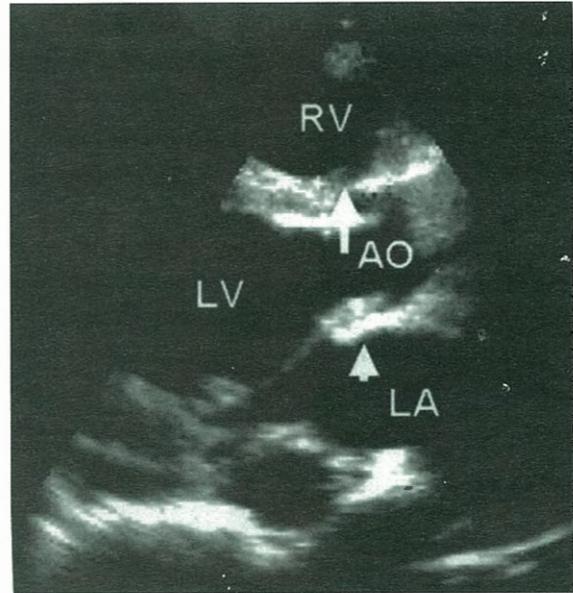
Parasternal long-axis examination from the patient after anatomic repair of penetrating cardiac trauma. Patches are noted in the area of the membranous ventricular septum (arrow), and in the area of fistulous connection between aorta and left atrium (arrowhead). LV: left ventricle, LA: left atrium, RV: right ventricle, AO: aorta.
